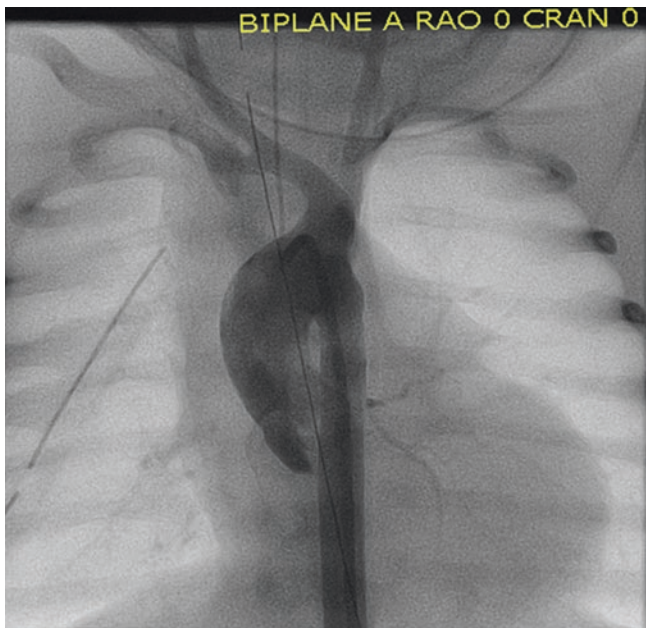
Patient 3. Acute modified Blalock-Taussig shunt (mBTS) occlusion. A 2-week-old 2.9 kg baby girl with hypoplastic right heart structures underwent placement of a 3.5 mm right mBTS from the right subclavian artery to the right pulmonary artery. Soon after arrival in the intensive care unit, she was noted to be desaturated with no audible shunt murmur, and no mBTS flow seen by echocardiogram. She was taken urgently to the cardiac catheterization laboratory for mBTS recanalization. The occluded mBTS is seen with an occluded beak seen from the right subclavian artery
